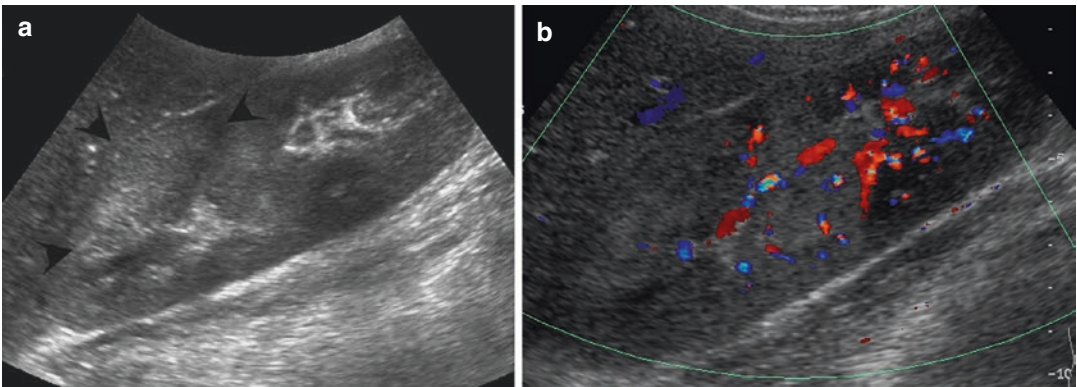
Acute pyelonephritis. The (a) shows an echogenic mass in the upper part of the left kidney (*arrowheads*). At color Doppler (b), the mass appears without vascularization, confirming the diagnosis
